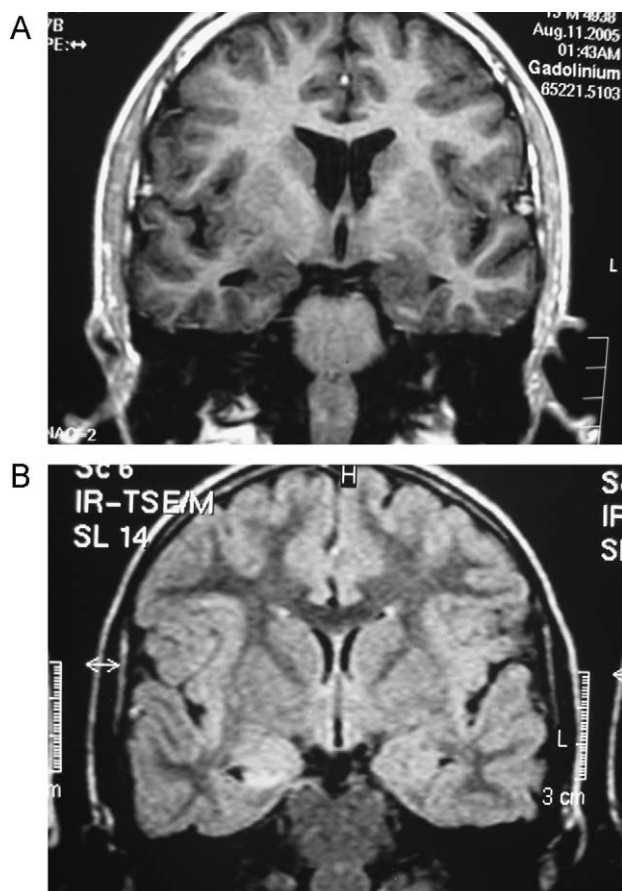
(A) Coronal T1-weighted image showing right hippocampal atrophy. (B) Coronal T2, FLAIR image shows hyperintense signal in the right hippocampus
